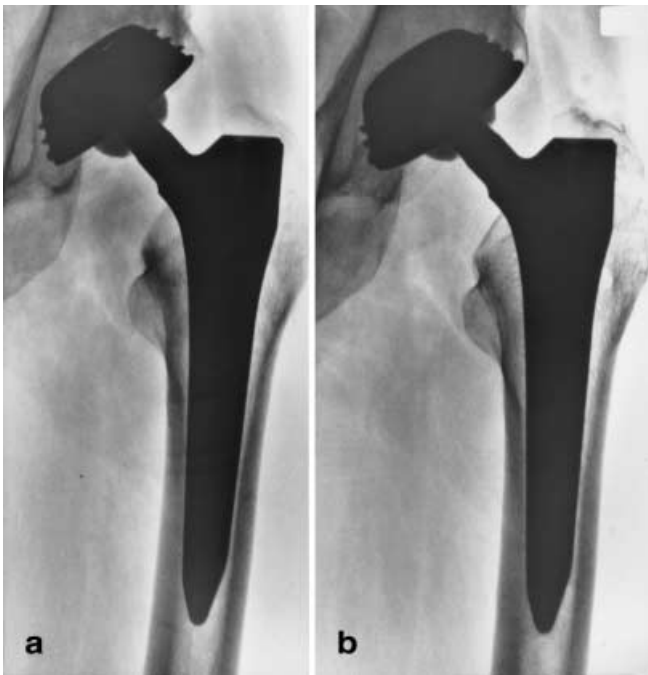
Male patient, 56 years. a Immediately postoperative, incomplete bone contact at the Uni-stem in zones II and III on the anteroposterior radiograph without any adverse effects on stability and osseointegration postoperatively (radiolucency Type 0, remodelling Type 1). b No adverse effects on stability at five years. Newly formed trabecular bone in zone III, indicative of load transfer and osseointegration. At final follow-up, the situation was radiographically unchanged around the Hofer-Imhof cup. No radiolucency (radiolucency Type 0)
